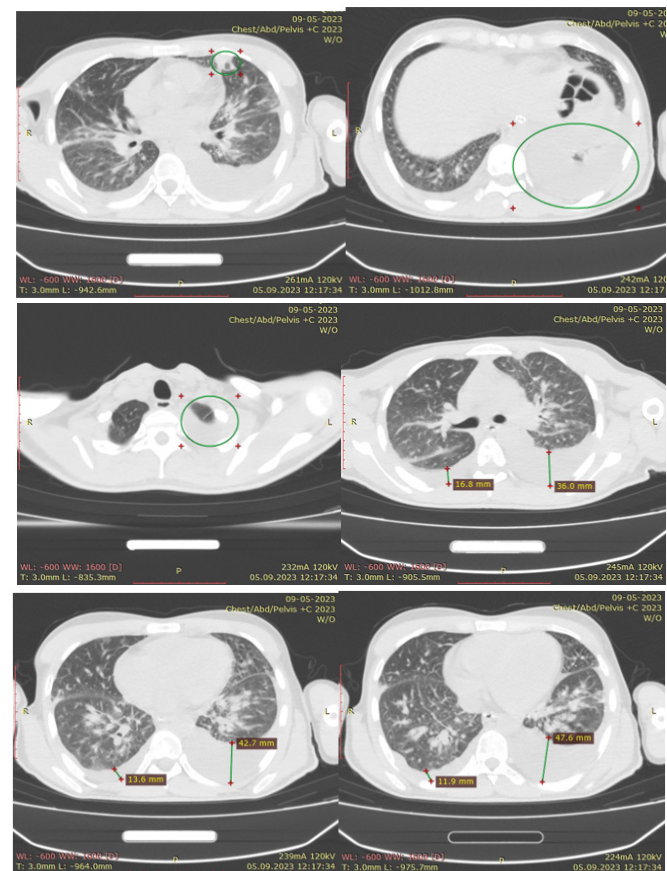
PET-CT evaluation during Trastuzumab treatment (May 2023).
